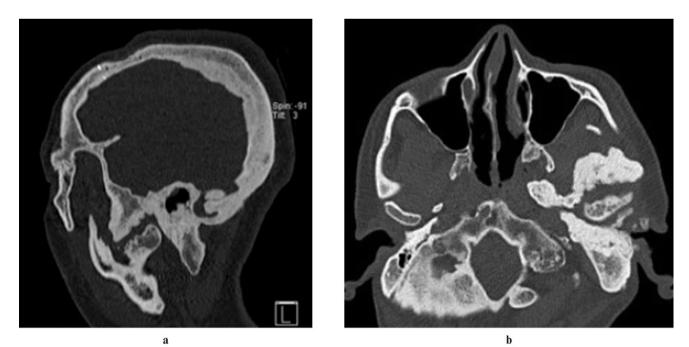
(a) Sagittal multiplanar reformat demonstrating extensive degenerative changes of the left temporomandibular joint with pseudoarticulation of the coronoid process anteriorly. (b) Axial image of the three dimensional CT reveals hypertrophic changes of the temporal bone and mandibular condyle with accompanying degenerative changes
